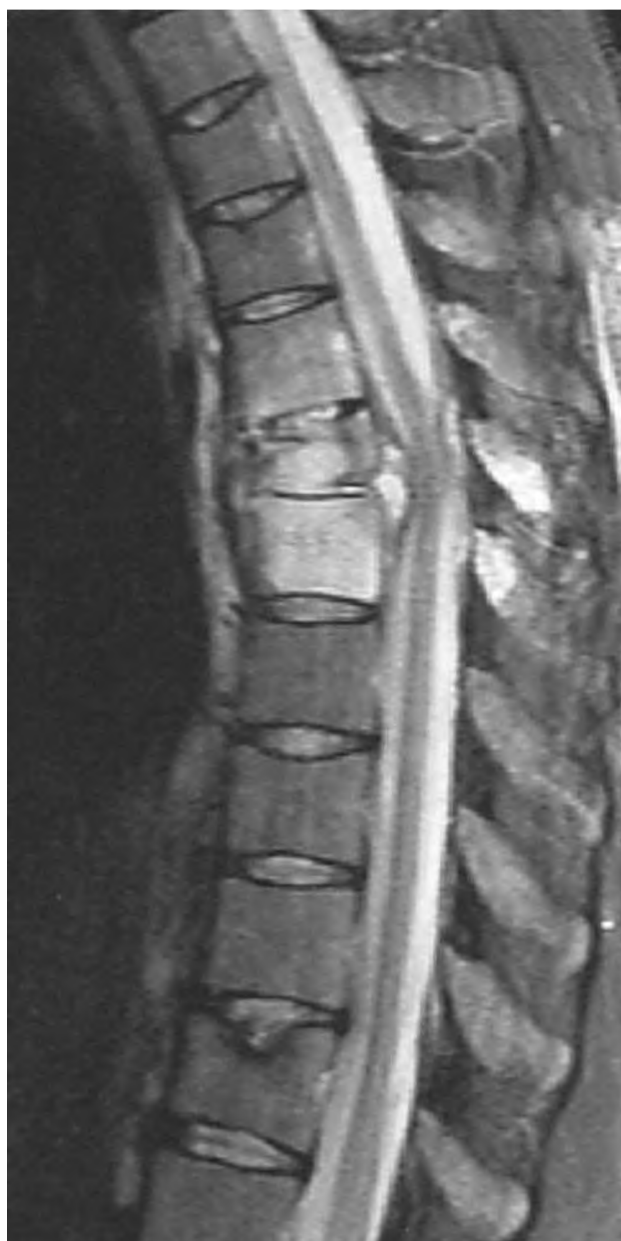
MRI demonstrating vertebral osteomyelitis T6 and T7 with spinal abscess causing compression of the spinal cord.
